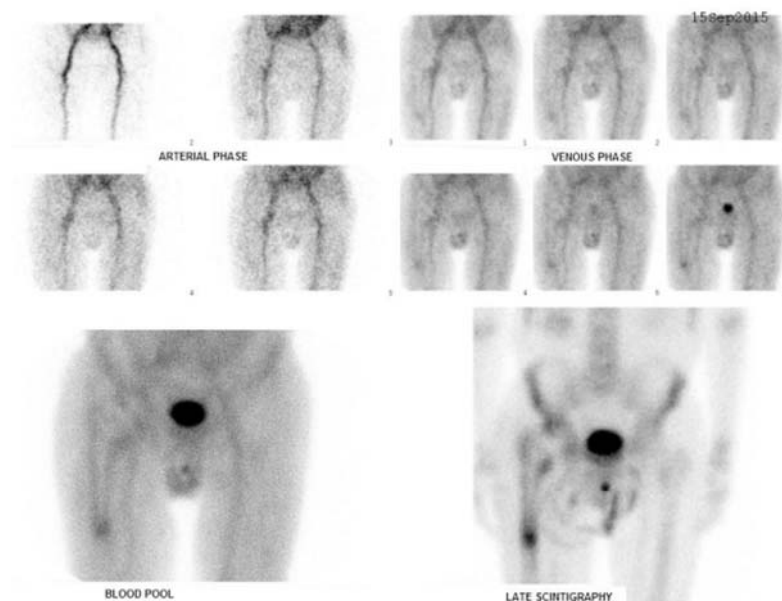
Aseptic instability of right hip prosthesis. 3-phase ^{99m}Tc – methylene diphosphonate (^{99m}Tc -MDP) scintigraphy finding was positive (patient No. 12).
